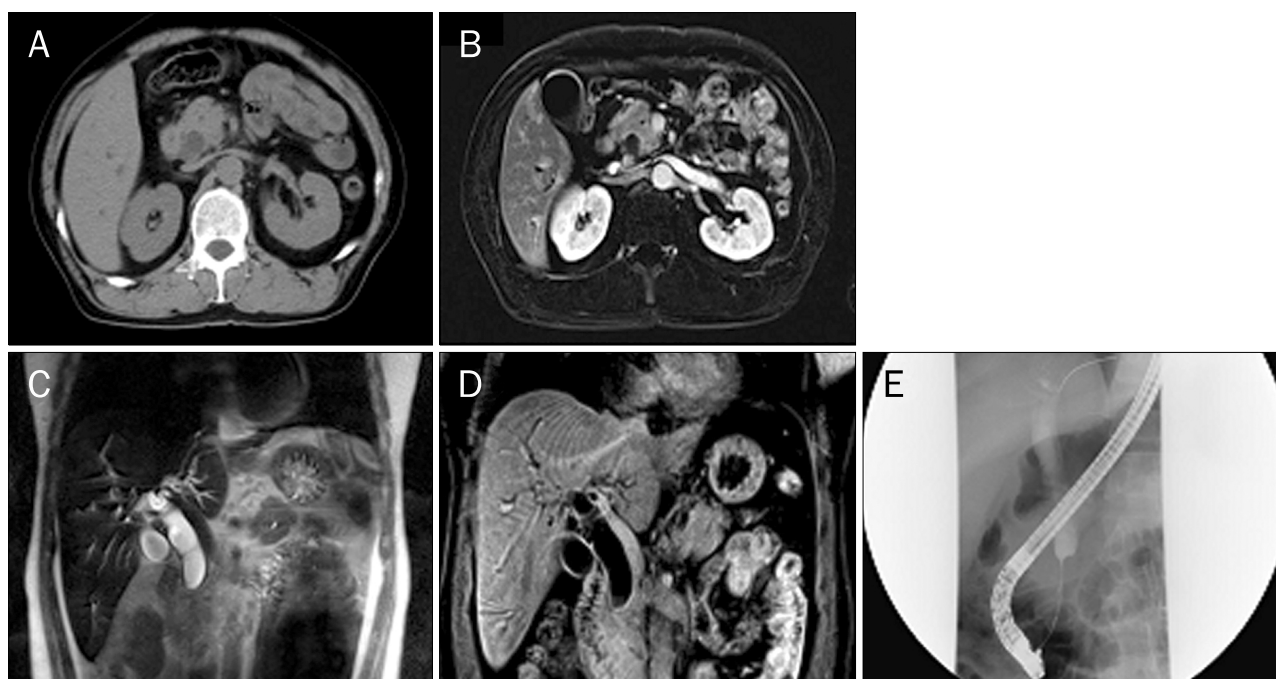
CT scan images and fluoroscopic findings. (A) An axial CT image shows a prominent enlarged pancreatic duct and mild peripancreatic infiltration around pancreatic head and uncinate process. Iso-attenuating distal bile duct cancer cannot be ruled out as the peripancreatic duct is not delineated clearly. (B-D) In addition to a CT image suspicious for malignancy, axial and coronal MRI show a distal common bile duct (CBD) obstruction and proximal bile duct dilatation with mild peripancreatic infiltration with pancreatic duct dilatation. (E) A cholangiogram obtained by ERCP. Abrupt narrowing distal CBD and dilatation of proximal bile duct are seen in this image.
